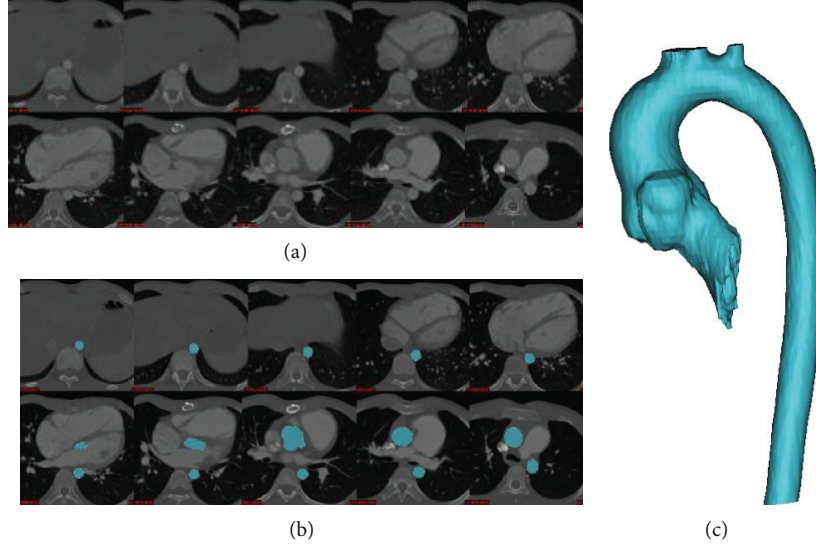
CT-based model construction process. (a) Selected CT slices from a patient, under diastolic pressure; (b) segmented results of the aorta; (c) reconstructed 3D geometry of the aorta.
